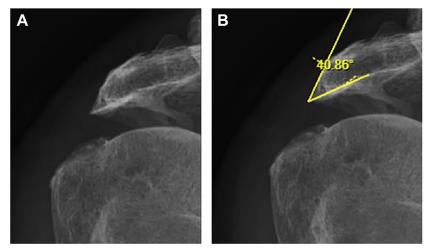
Radiographic image of the sharpened lateral acromion morphology (*A*), with the ILAA measured at 40° (*B*), consistent with an SLAM sign. (*From* Amit P, Paluch AJ, Baring T. Sharpened lateral acromion morphology (SLAM sign) as an indicator of rotator cuff tear: a retrospective matched study. JSES Int. 2021 Jul 14;5(5):850-855. https://doi.org/10. 1016/j.jseint.2021.05.013. PMID: 34505095; PMCID: PMC8411071.)
